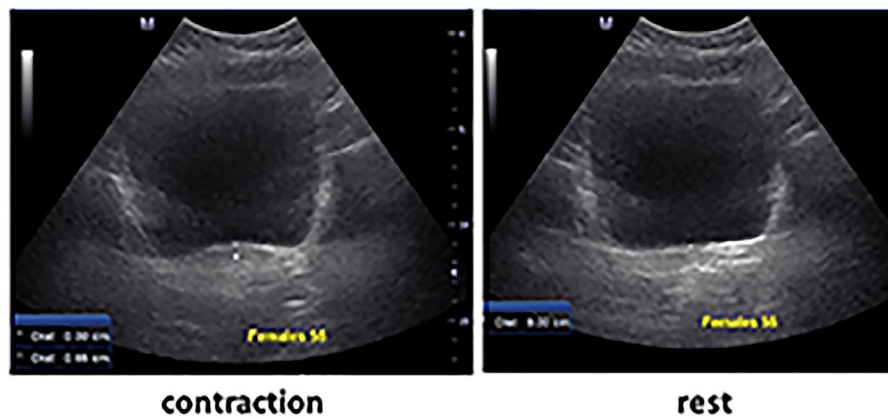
Ultrasound assessment of pelvic floor displacement during rest (right) and contraction (left)
